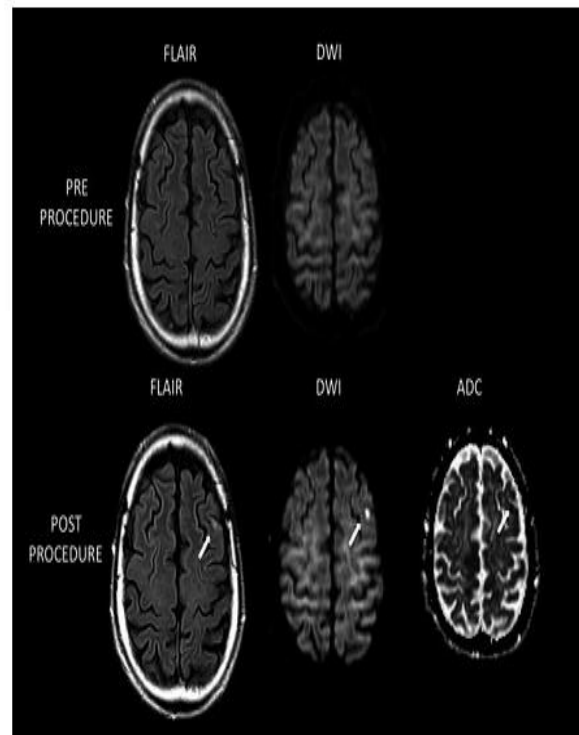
Preprocedural and postprocedural cerebral MRI, with T2-weighted FLAIR, DW image (DWI), and apparent diffusion coefficient (ADC) map. White arrows indicate a bright lesion in the cortical-subcortical left frontal region corresponding to a signal hypointensity in the apparent diffusion coefficient map, consistent with acute embolic cerebral infarction.
